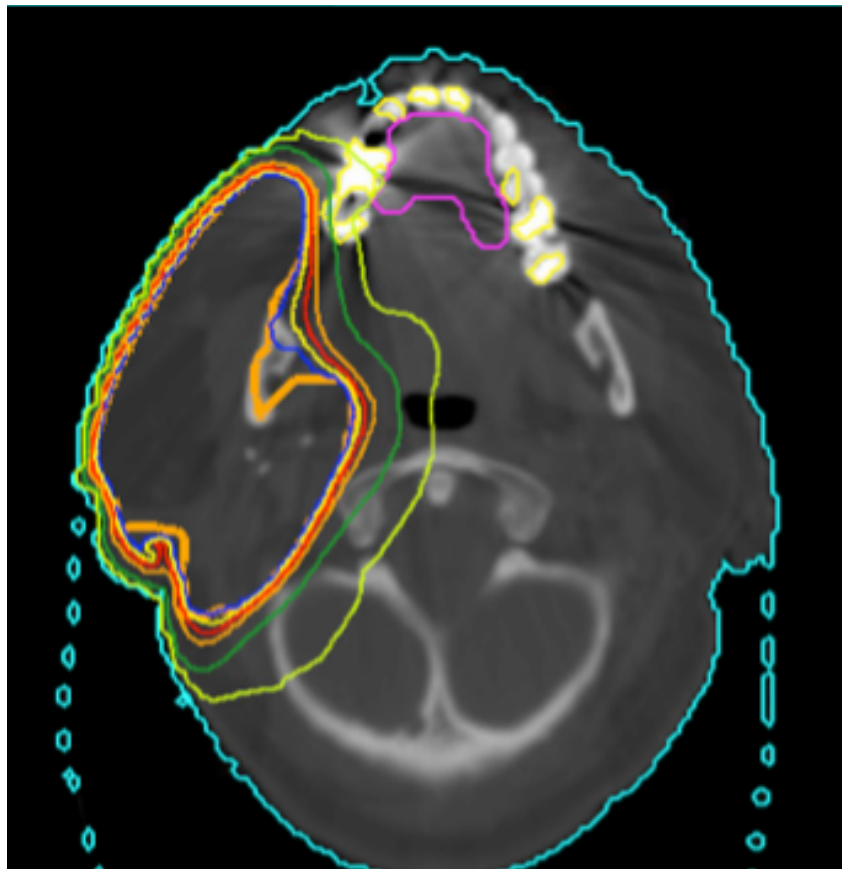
This is a slice of a CT scan showing how dental implants and surrounding tissues were contoured. The implants are contoured in bright yellow on the patient's teeth and the surrounding tissues are contoured in bright pink just inside the patient's teeth.
